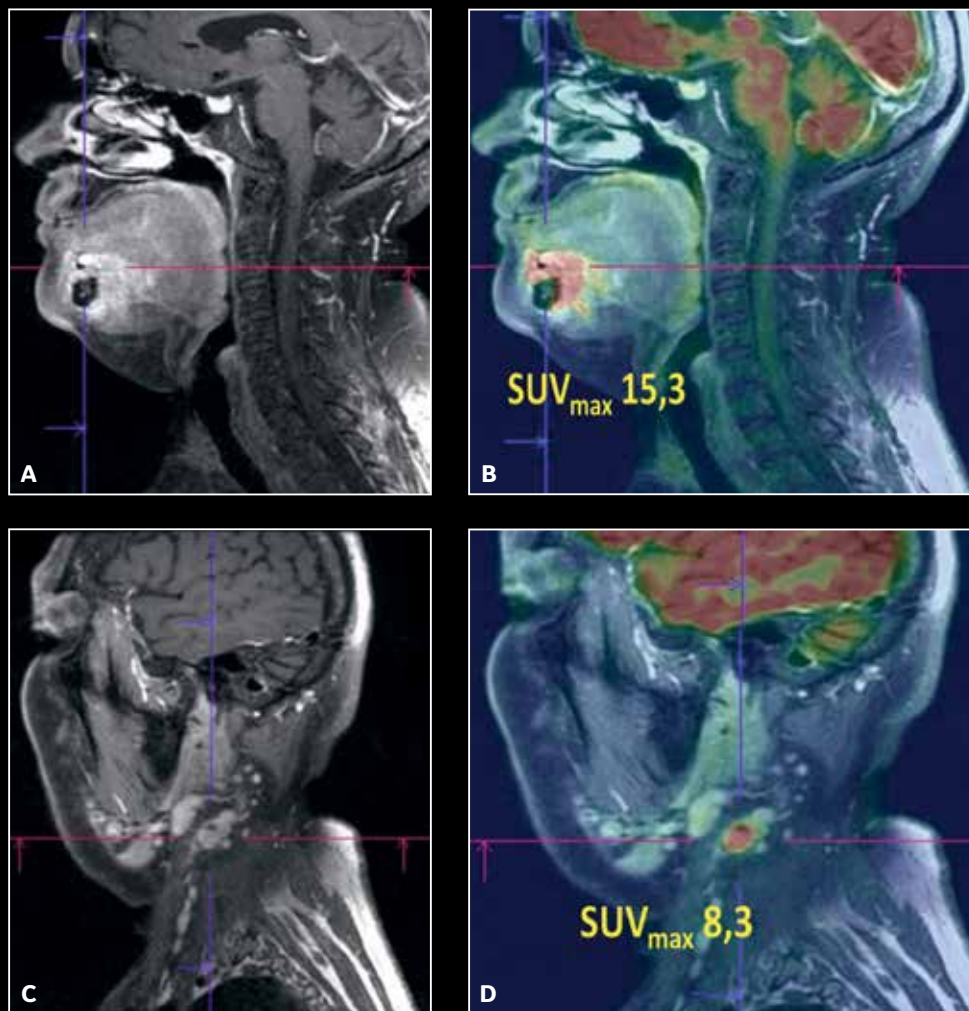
Pre-surgical assessment of a mandibular gingiva squamous cell carcinoma with FDG PET/MR imaging. MR findings: mandibular gingiva lesion with trabecular bone invasion, left necrotic lymph node. PET findings: hypermetabolism of the lesion and the left lymph node. Pathology confirms PET/MR findings.
